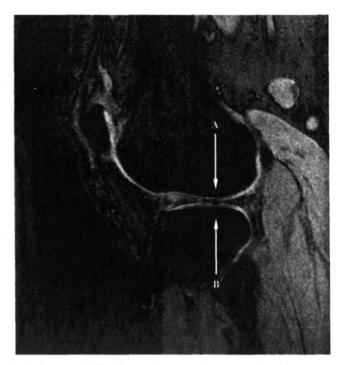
T_1 -weighted MRI of Grade 3 femoral cartilage defect (A) and Grade 2 tibial cartilage defect (B).
